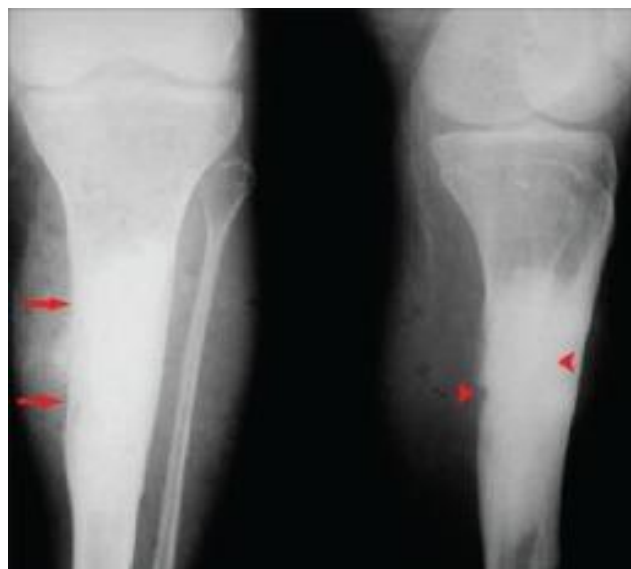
X-ray of proximal tibia and knee joint showing diaphyseal osteosarcoma of tibia with sclerosis (arrow), cortical destruction (arrow heads) and new bone formation in the soft tissues. Adapted from¹³
